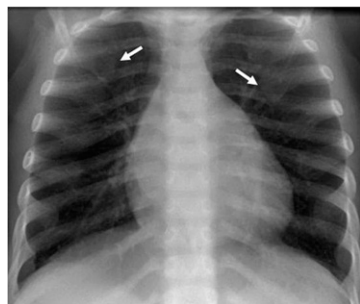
Chest radiograph demonstrates prominent metaphyseal widening at the costochondral junction anteriorly, also known as "rachitic rosary" (white arrows).
